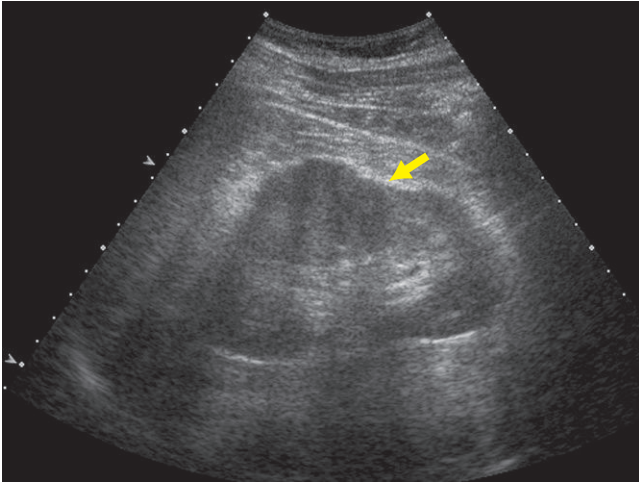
Ultrasound of the left kidney demonstrates the appearance of a hypoechoic mass within the mid pole of the left kidney causing bulging of the kidney (arrow).
